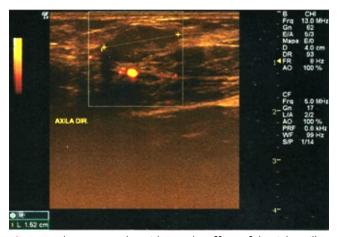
Ultrasonography, with Doppler effect, of the right axilla.
